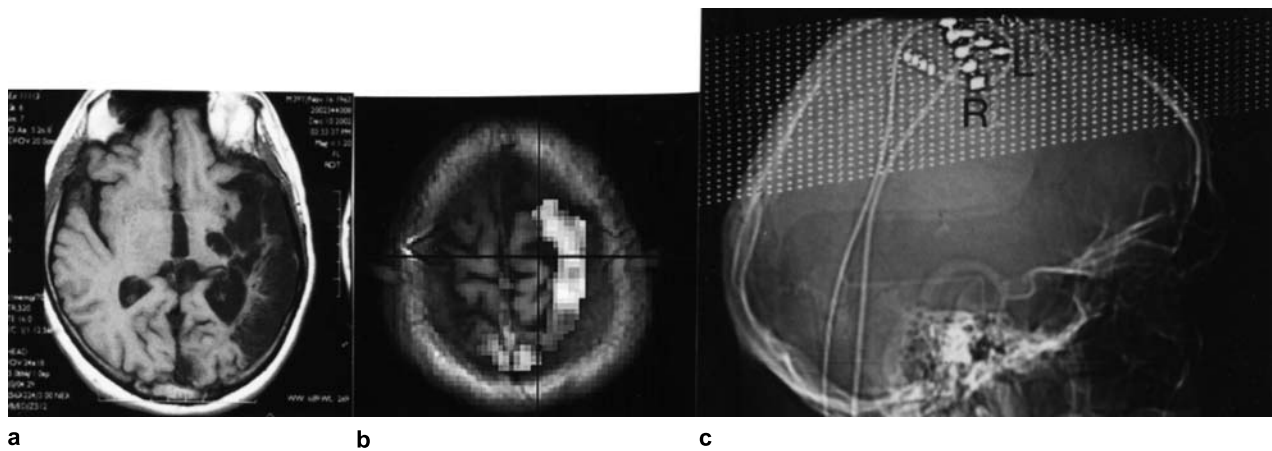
MR image of a patient with stroke (a), fMR image following motor activation of the paretic arm (b) and double cortical stimulator ion motor areas (c) (Ref. [10b])
